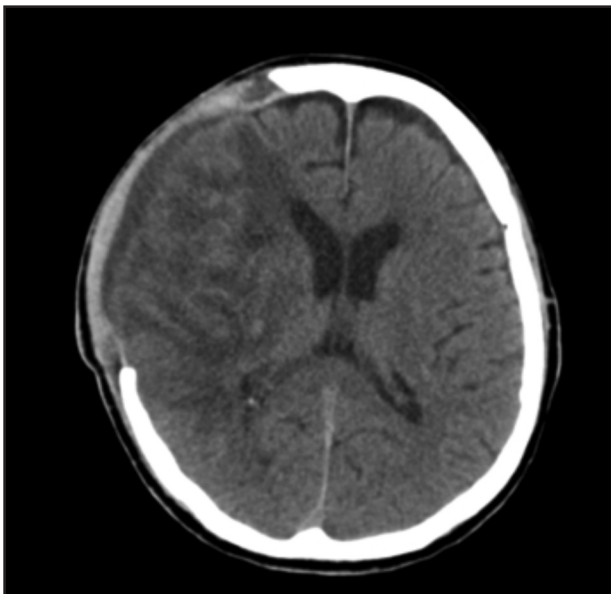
Repeated CT Brain post right parieto-temporal craniotomy. Previously seen right MCA infarct with haemorrhagic transformation showed involution changes with less perilesional oedema.
